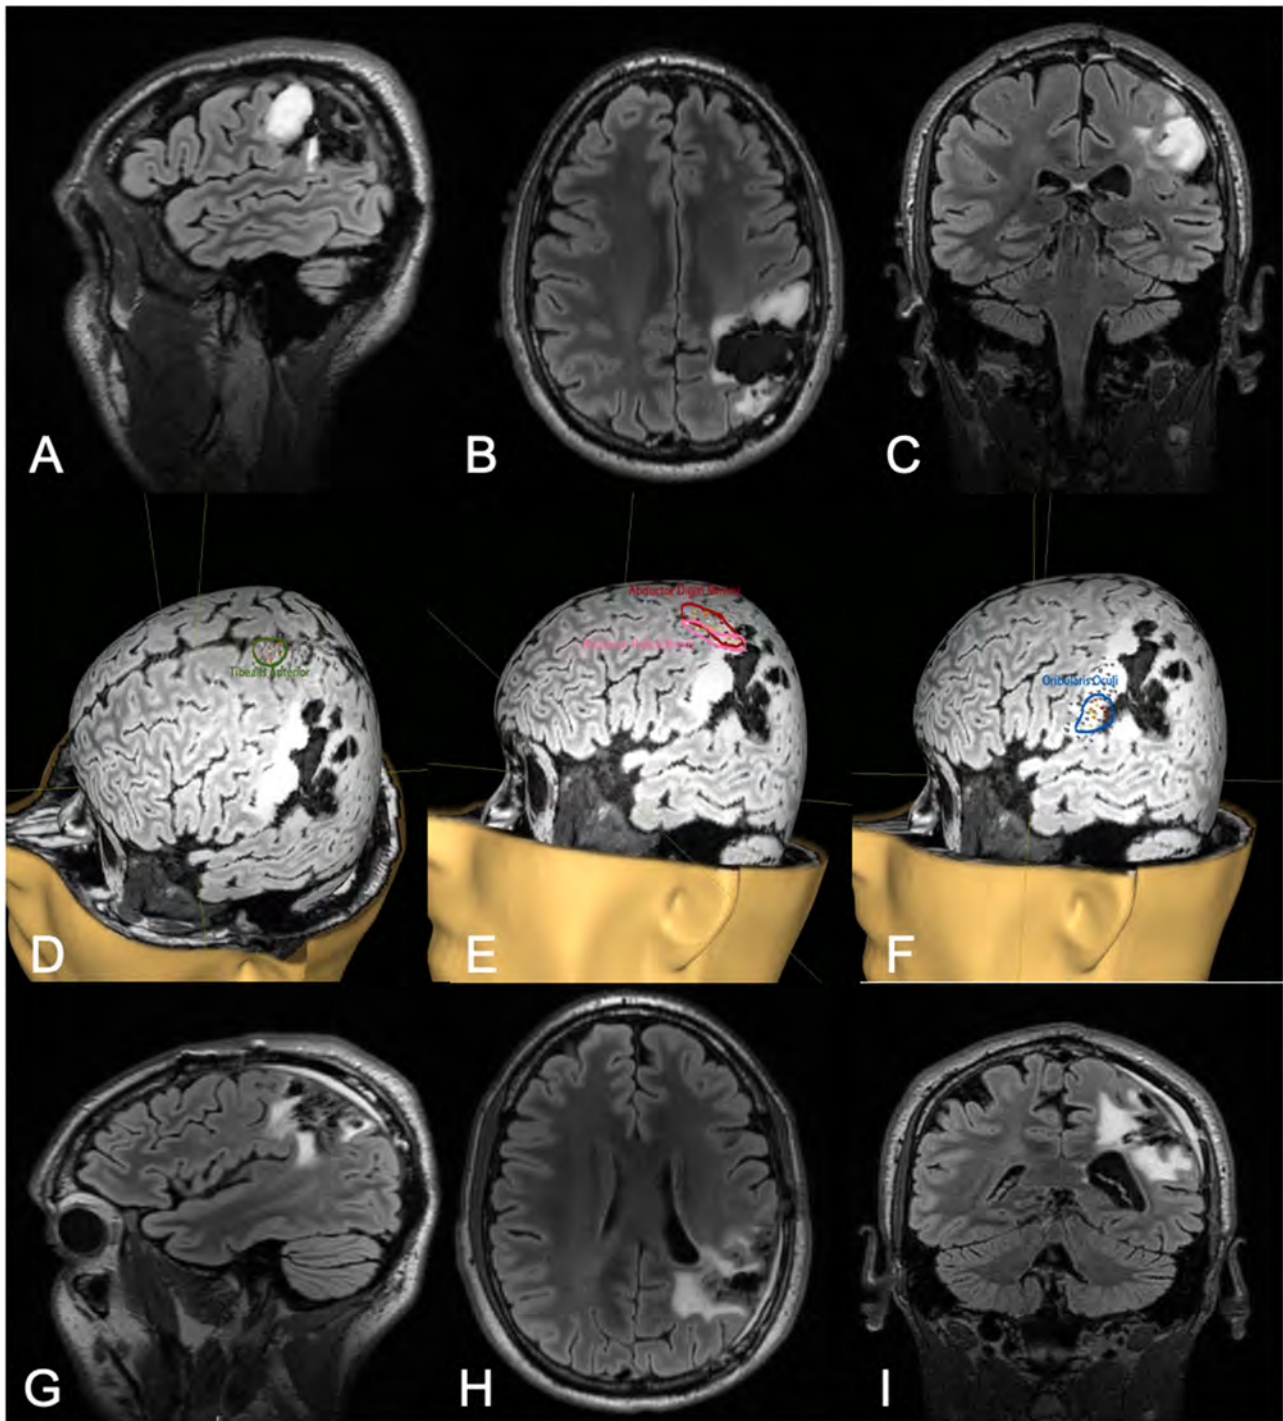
Thirty-two-year-old male with a history of left parietal oligoastrocytoma status post prior resection, now presenting with recurrence (T2 FLAIR imaging, A–C). nTMS demonstrated hand motor responses anterior to the region of recurrence, face motor responses entirely within the recurrence, and leg motor responses anterior to the recurrence (D–F). Intraoperative DCS identified hand and upper extremity function in close proximity to, and at times continuous with, the area of recurrence. Subtotal resection was achieved with care taken to spare hand and face motor sites intraoperatively (T2 FLAIR imaging, G–I). The patient had no postoperative neurological deficits on neurological examination.
